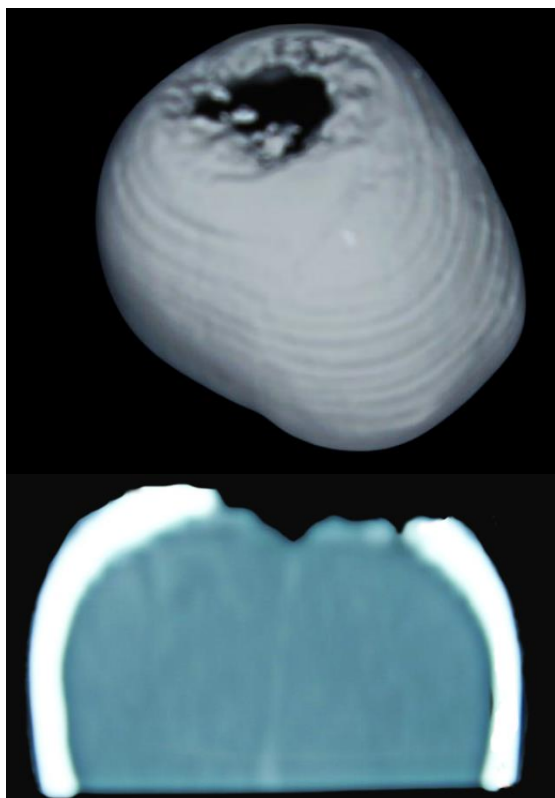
CT scan of the head (bone window) (Department of Neurosurgery Zenica Cantonal Hospital)
